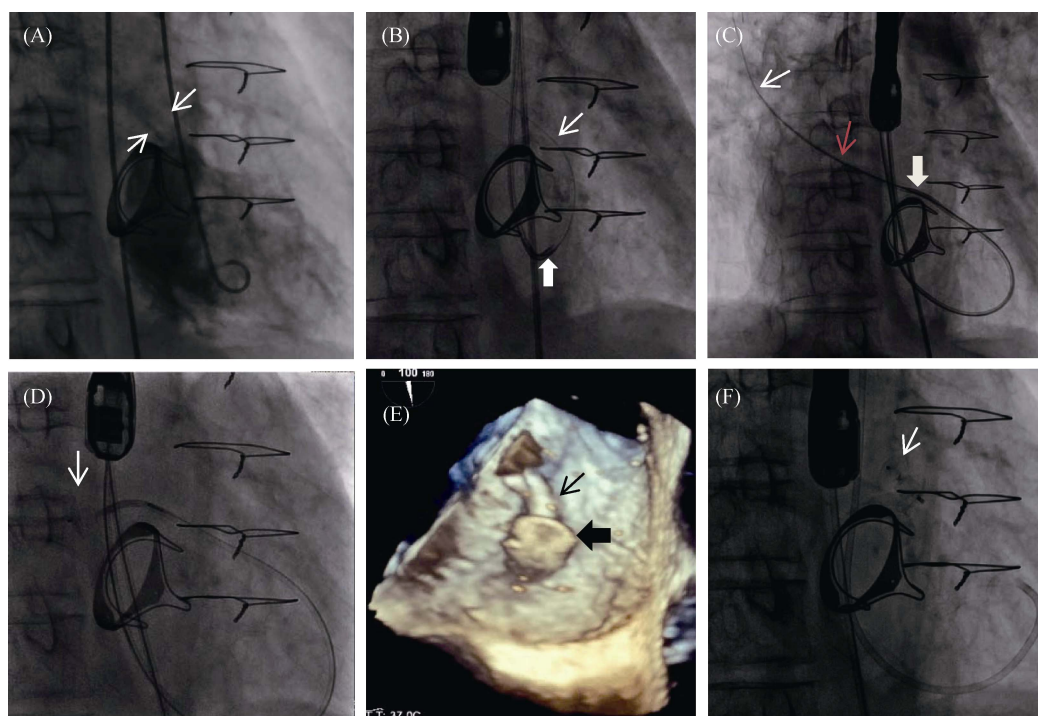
Fluoroscopic and 3D-TEE images showing mitral PVL and its sealing with occluder. (A): The left ventriculogram demonstrating severe mitral regurgitation (white arrows); (B): Fluoroscopic image showing the 0.025 inch J-tipped guidewire (white arrow) crossing through the PVL defect from the left ventricle to the left atrium but the 6F JR4 guiding catheter (bold white arrow) failed; (C): Fluoroscopic image showing the support of 0.035-inch Amplatzer[®] Super Stiff guidewire (white arrow) and 5F multipurpose guiding catheter (red arrow) as a mother-in-child catheter technique, the 6F JR4 guiding catheter (bold white arrow) crossed the defect; (D & F): deployment of ADO II guided by fluoroscopy (white arrow pointing ADO II) and (E): 3D-TEE (black arrow pointing 6F JR4 guiding catheter, bold black arrow pointing ADO II). 3D-TEE: three-dimensional transesophageal echocardiography; ADO II: Amplatzer[®] Duct Occluder II.
